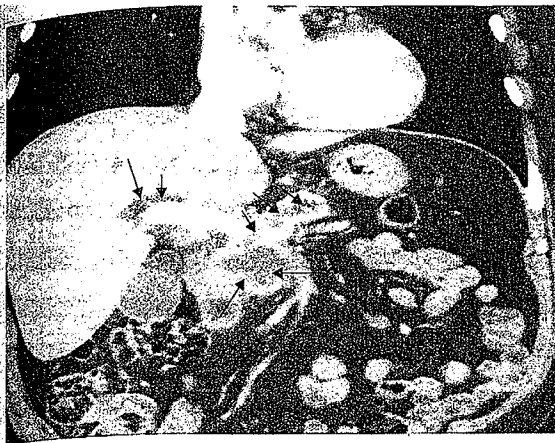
Coronal CT showing pancreatic cancer and dilated intrahepatic and pancreatic ducts (arrows).
